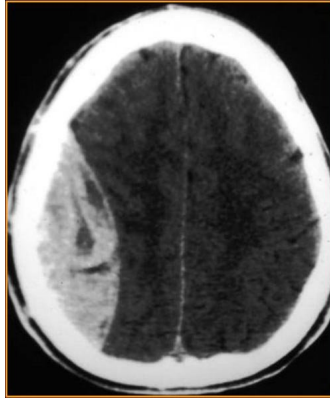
CT of Epidural Hematoma<sup>22</sup>
